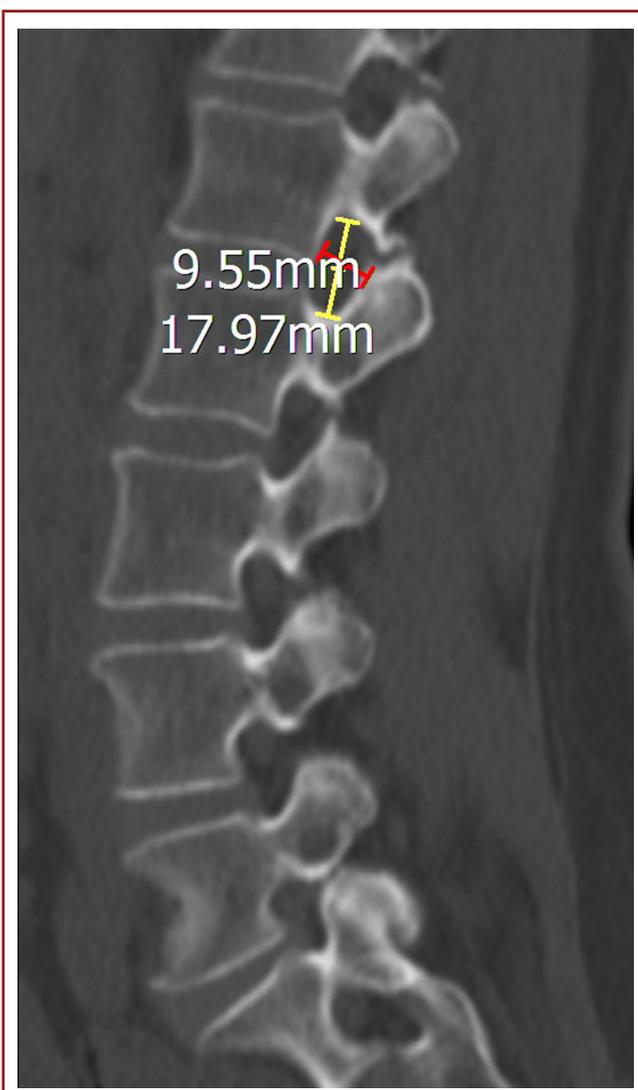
Sagittal reconstructive 3D-CT images used to measure all levels of lumbar level foraminal length and width.
